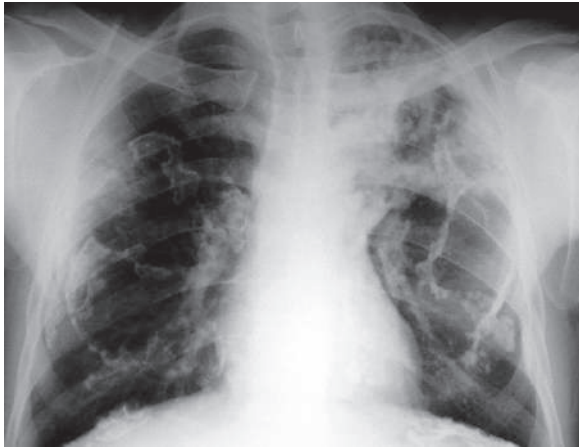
Posteroanterior chest radiograph of a patient with asbestosis shows bilateral calcified pleural plaques
